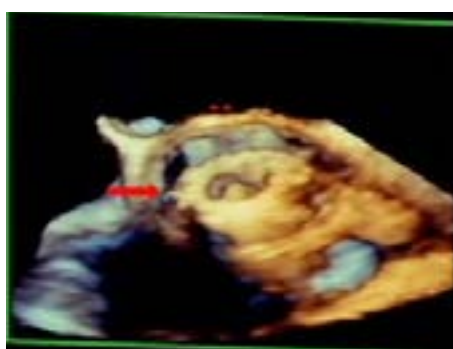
Transesophageal echocardiography indicted loose aortic valve (arrow) movement and aortic annulus.
